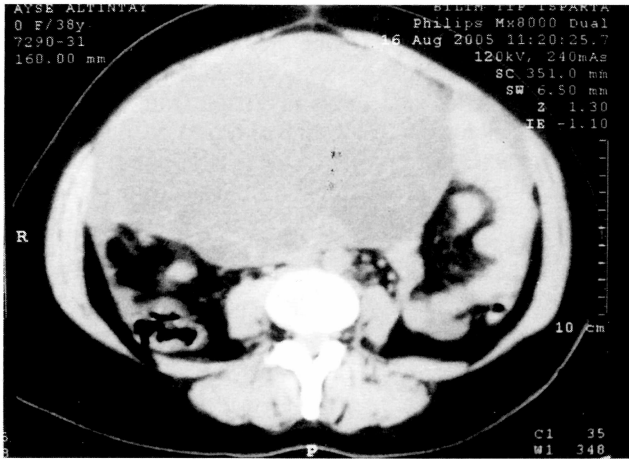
Computed tomography scan through the pelvis revealing a large complex right adnexal mass.
